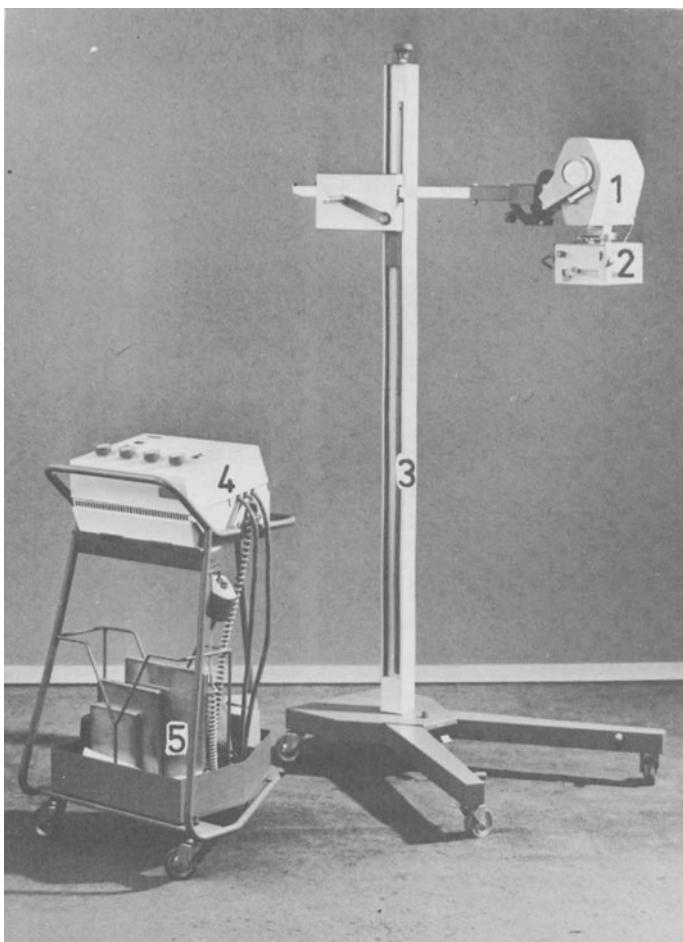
Mobile stand which can be dismantled. 1. X-ray tube (tank unit); 2. light-beam diaphragm; 3. column on a pedestal; 4. control desk with hand switch; 5. trolley for cassettes, which can be detached from the stand.
